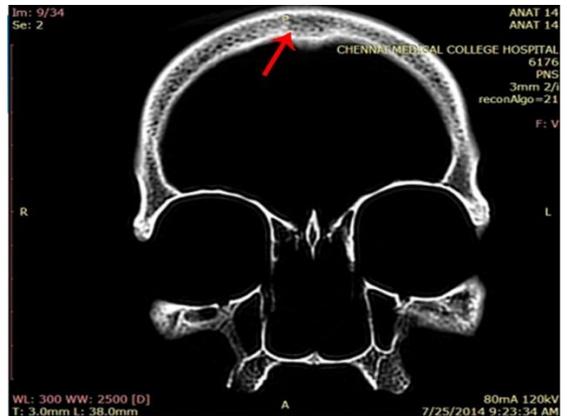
Coronal CT of incomplete metopic skull showing bilateral absence of frontal sinuses
